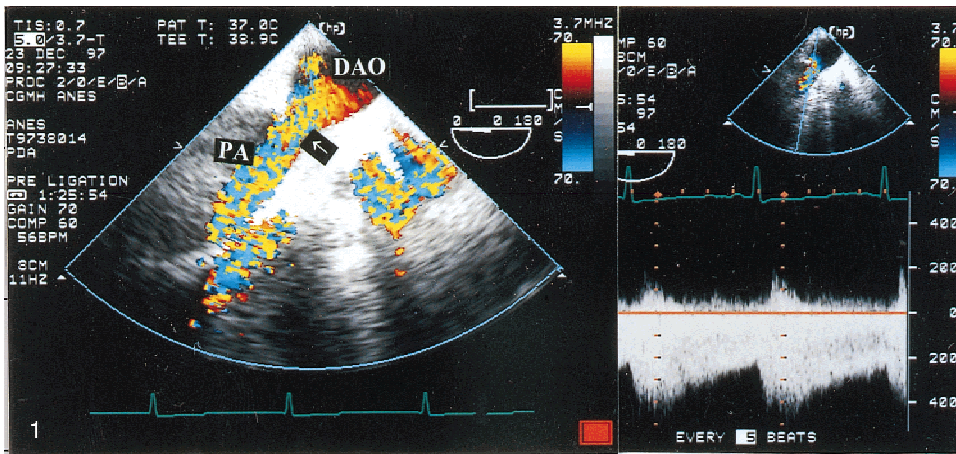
Left multiplane TEE of the descending aorta (DAO) in short axis. Color-flow Doppler imaging demonstrates a mosaic turbulent flow between the aorta and the pulmonary artery (PA) (arrow), identifying the PDA. Right continuous-wave Doppler showed high-velocity flow pattern.
